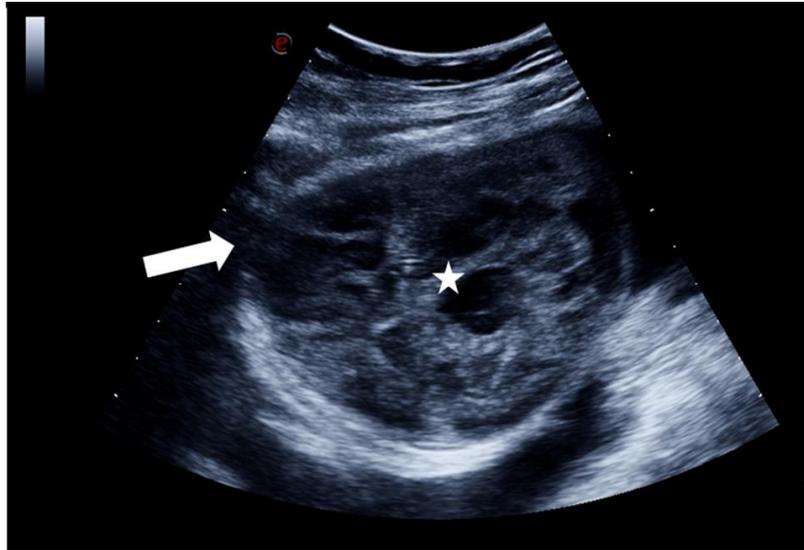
Foetal acalvaria; gray scale ultrasound of the foetal brain (3.5 mhz probe) in axial plane. Gestational age 38 weeks. No skull seen around the brain (arrow). Asterisk indicates the inter-hemispheric fissure
